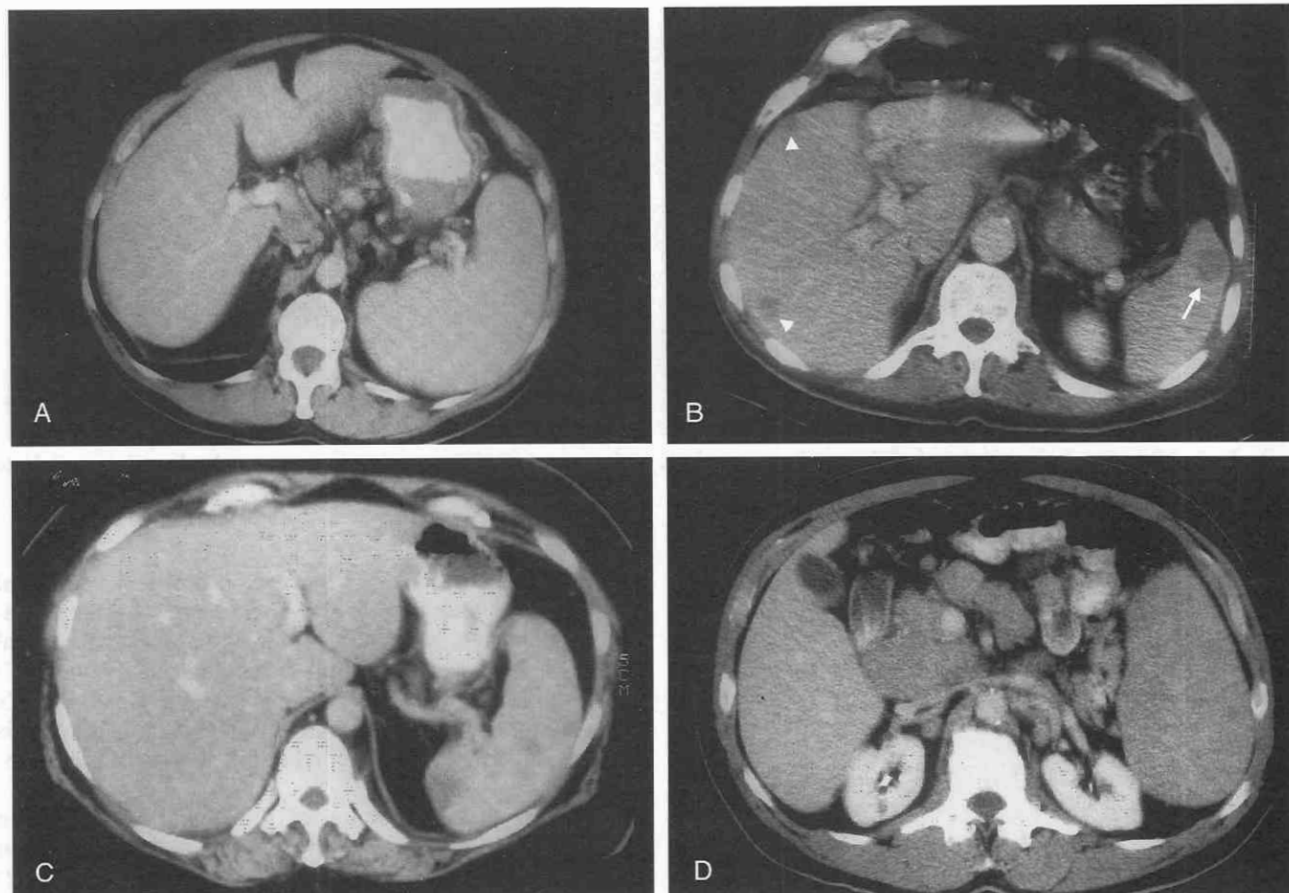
CT scans of splenic lymphoma. *A*, Spleen of a patient with non-Hodgkin's lymphoma and diffuse splenic enlargement with no focal splenic lesions. *B*, Spleen of a patient with non-Hodgkin's lymphoma reveals a focal low-attenuation splenic lesion (arrow). There are focal low-attenuation lesions in the liver as well (arrowheads). *C*, Multifocal low-attenuation splenic lesions in a patient with non-Hodgkin's lymphoma. *D*, Diffuse low-attenuation splenic infiltration can be seen in this patient with non-Hodgkin's lymphoma. Retroperitoneal and peripancreatic adenopathy is present as well.
